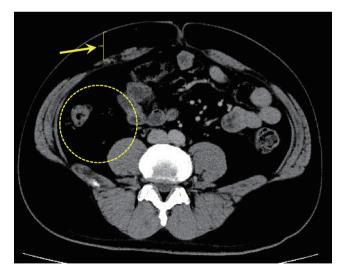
Abdominal computed tomography shows the thick abdominal wall (yellow arrow) with visceral obesity (circled yellow dots)
